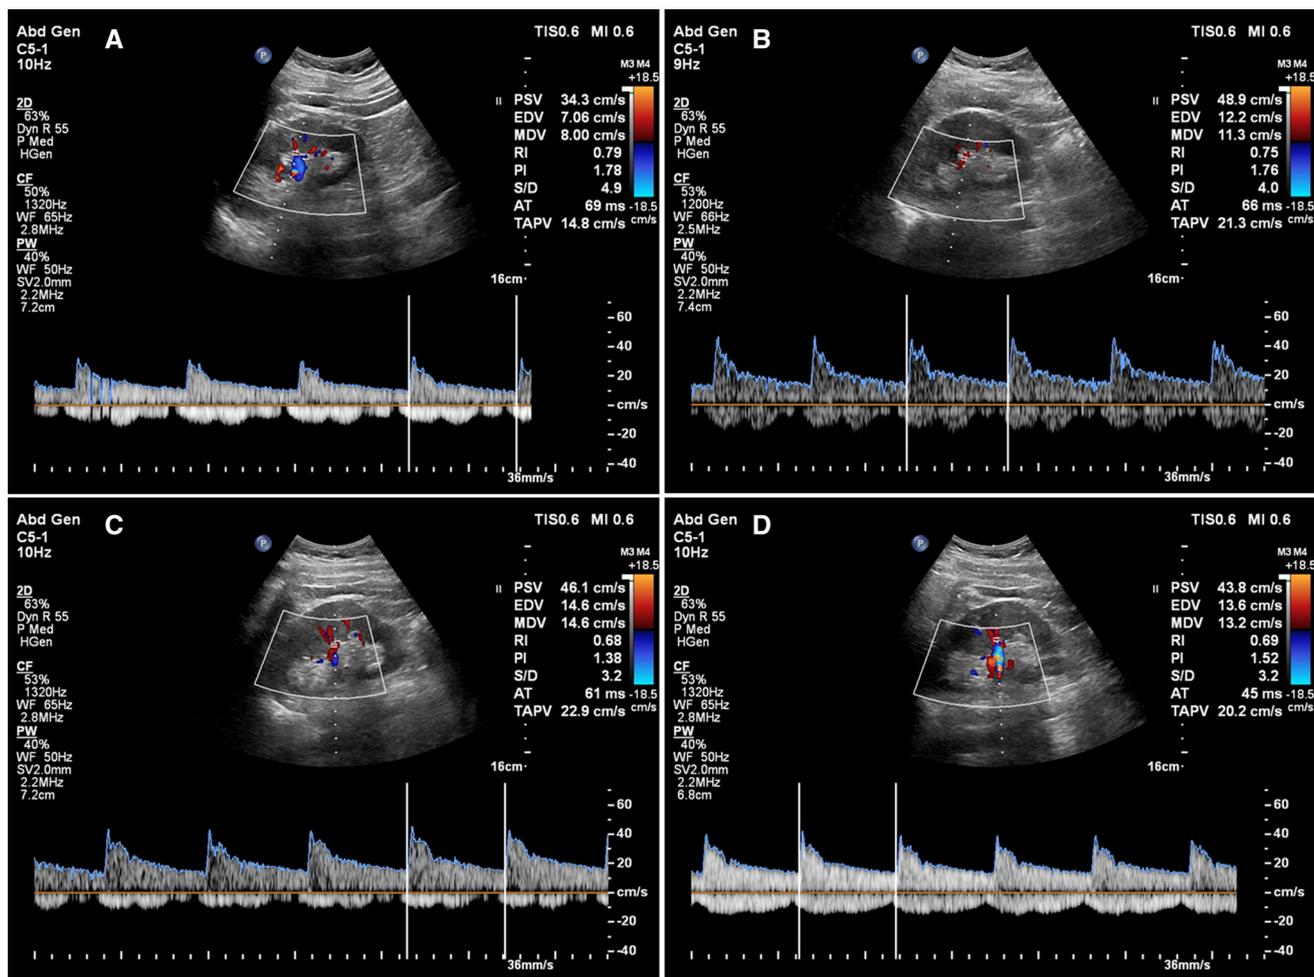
In hypertensive patient, renal resistive index (RRI) is measured by Doppler sonography in a right kidney intrarenal or intralobar artery and is the difference between the peak systolic (PSV) and end-diastolic (EDV) blood velocities divided by the peak systolic velocity (PSV)
